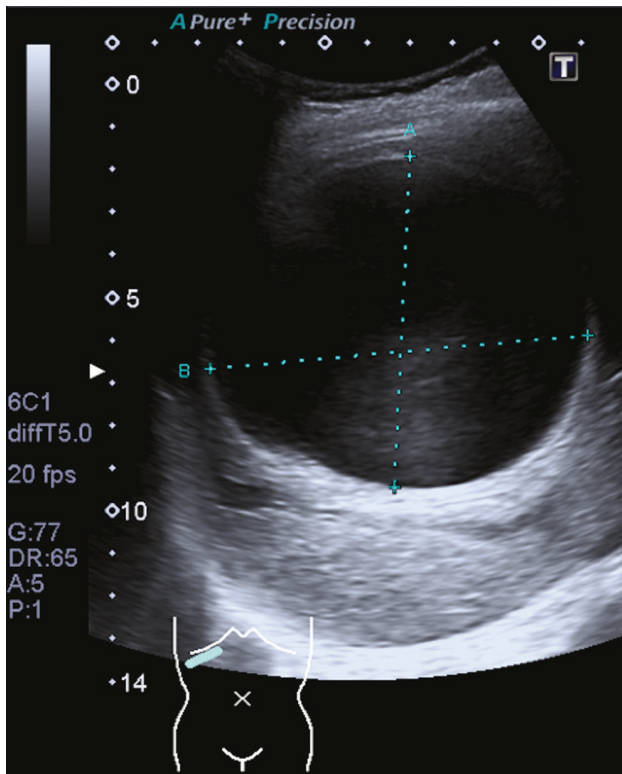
Abdominal ultrasound in a 55-year-old woman with diffuse abdominal pain shows a large cystic lesion with hyper-echogenic margins in the right lobe of the liver and posterior acoustic enhancement. Gharbi I-CE1.
